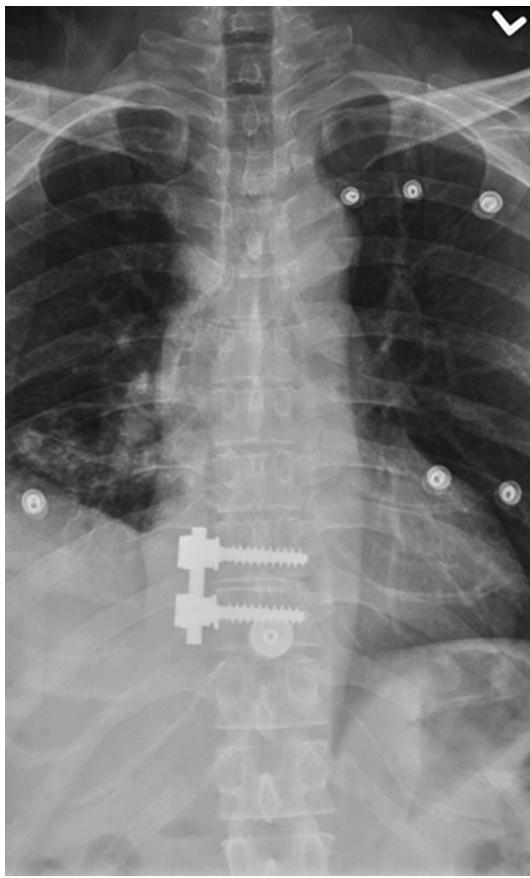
Postoperative thoracic spine X-ray one week after the exploration showed satisfactory implant position and no hemothorax
